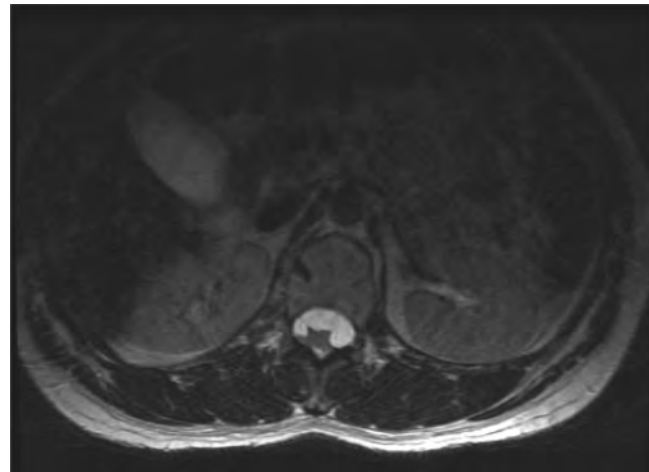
Arachnoiditis deforming thoracic cord (axial MRI).
